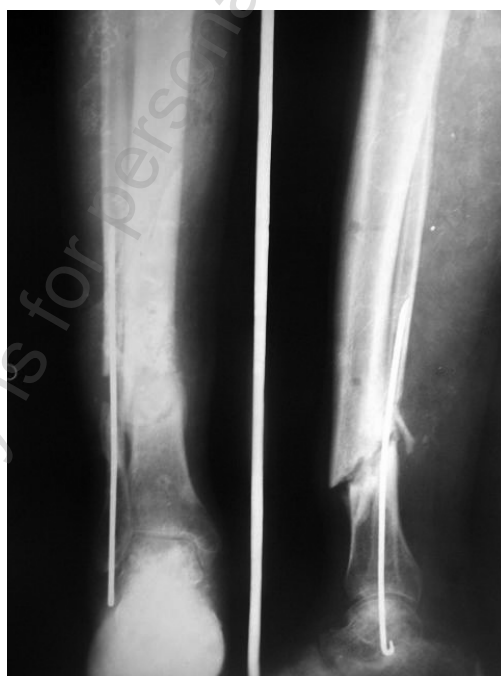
Pre operative radiograph of the infected distal tibial non union
